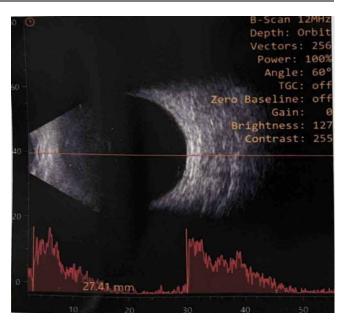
Ultrasound B Scan was done, showing a cataractous lens and a few vitreous opacities
